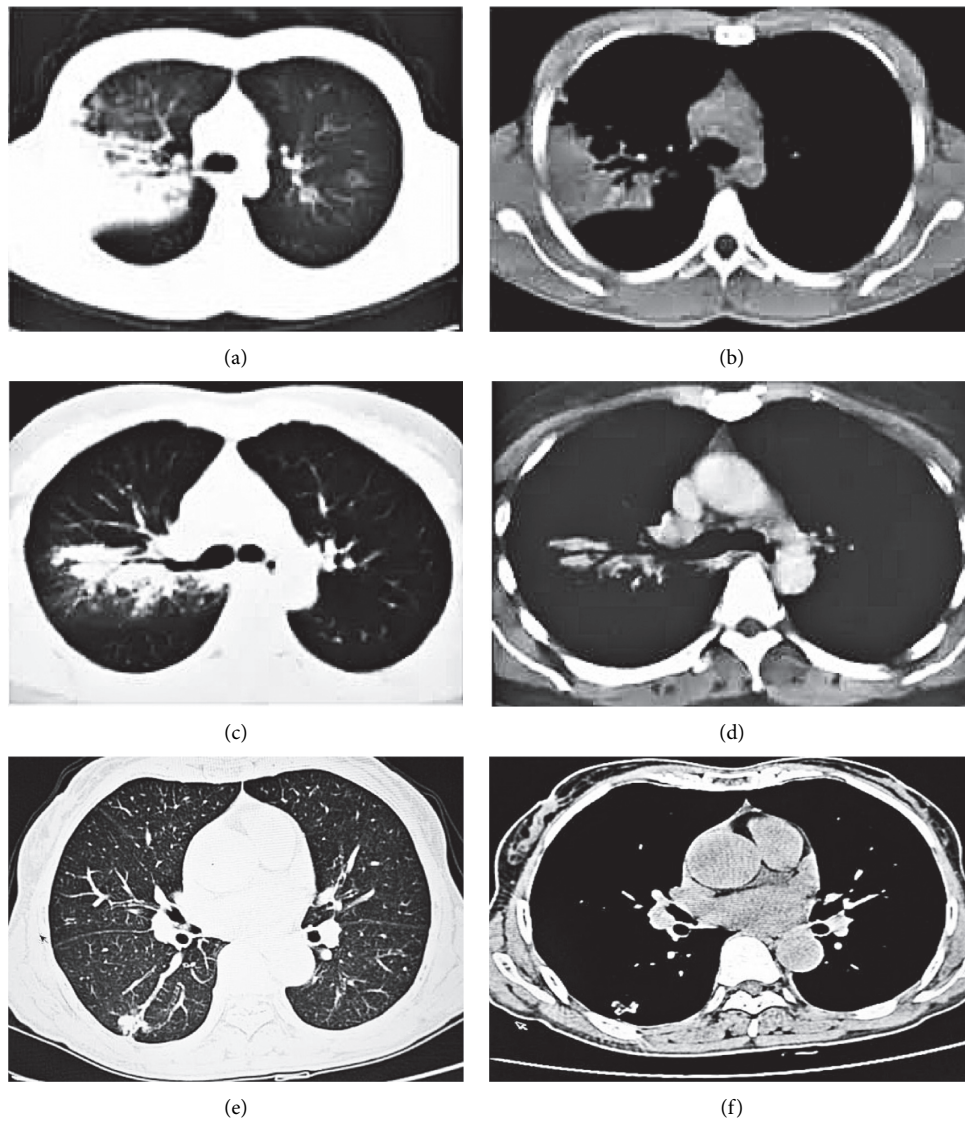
MRI images of children patients with lobar pneumonia: (a, b) CT images of the pulmonary window and mediastinal window of a male child patient (aged 5 years), respectively; (c, d) CT images of the pulmonary window and mediastinal window of a female child patient (aged 11 years), respectively; (e, f) CT images of the pulmonary window and mediastinal window of a male child patient (aged 12 years).
